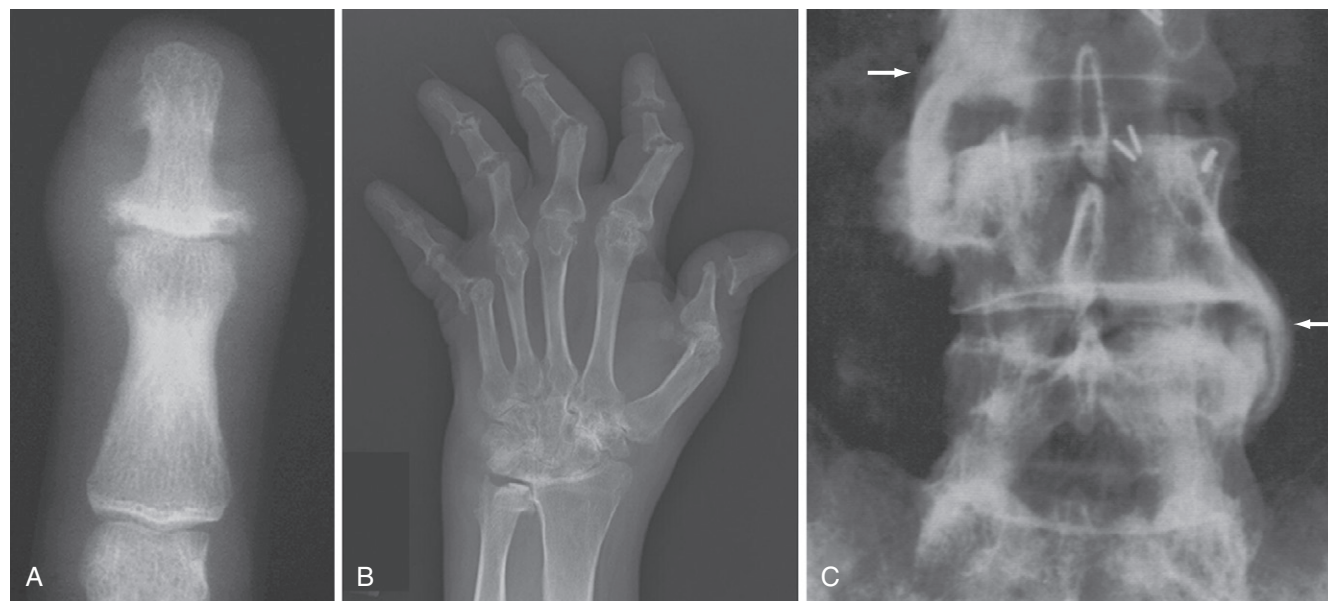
Psoriatic arthritis (x-ray). A, Distal interphalangeal joint with classic radiographic findings, including soft tissue swelling, bone erosions with accompanying bone proliferation, and lack of osteoporosis. B, Arthritis mutilans resulting from psoriatic arthritis with destructive changes and joint deformity of the hand and pancompartmental ankylosis of the wrist. C, Psoriatic spondylitis. Thick asymmetric paravertebral ossifications (arrows), which are characteristic of psoriatic spondylitis and reactive arthritis. (From Resnick D, Niwayama G: *Diagnosis of bone and joint disorders*, Philadelphia, 1988, WB Saunders.)
